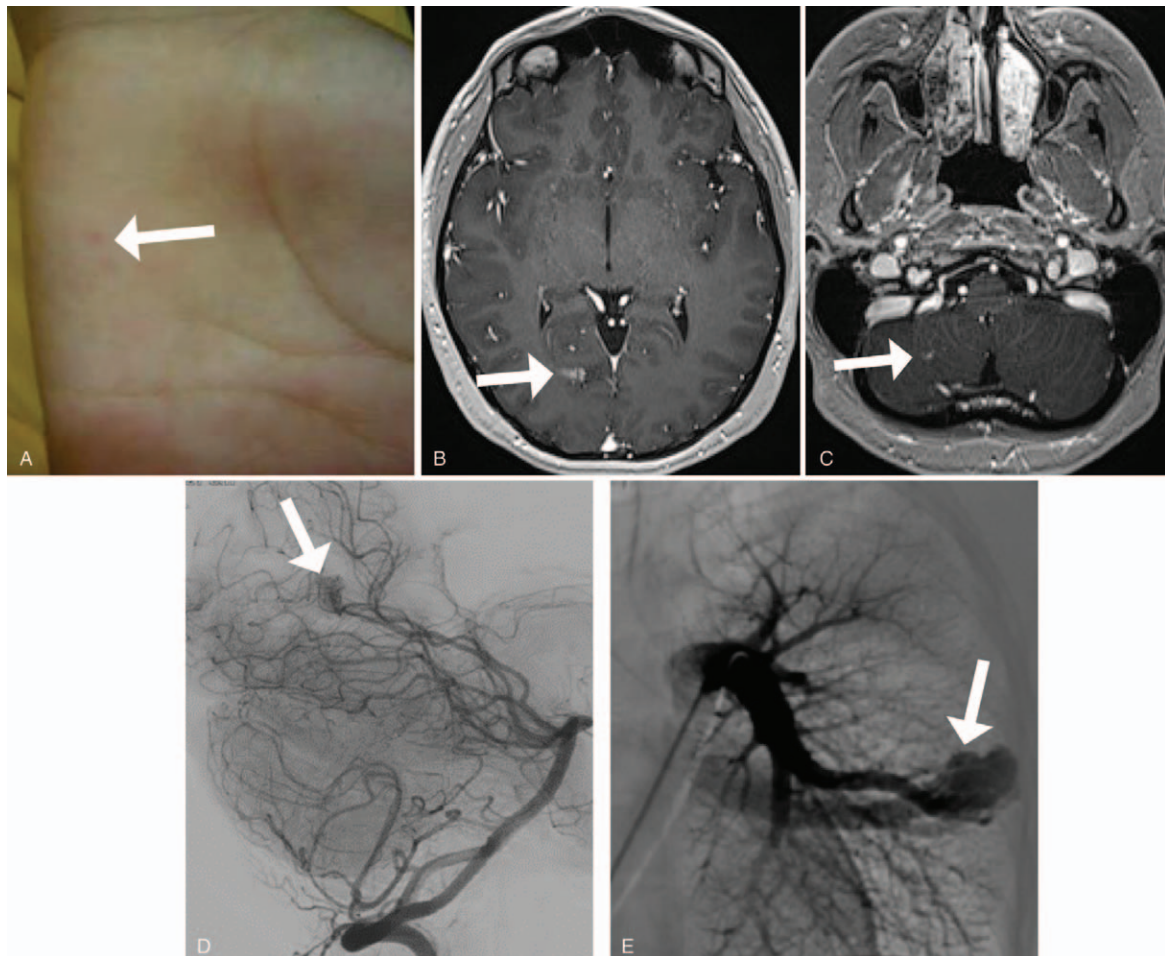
26-Year-old woman with HHT. Cutaneous telangiectasia in the palm of the left hand (white arrow in A). Axial contrast-enhanced T1-weighted images (B and C) show ill-defined areas of enhancement in the right occipital lobe (white arrow on B) and in the right cerebellar hemisphere (white arrow on C), compatible with small arteriovenous malformations. Digital cerebral angiography (D) shows a small AVM in the right occipital lobe (white arrow), supplied by the calcarine artery. Digital pulmonary angiography (E) shows a high-flow pulmonary AVM in the left lung (white arrow).
